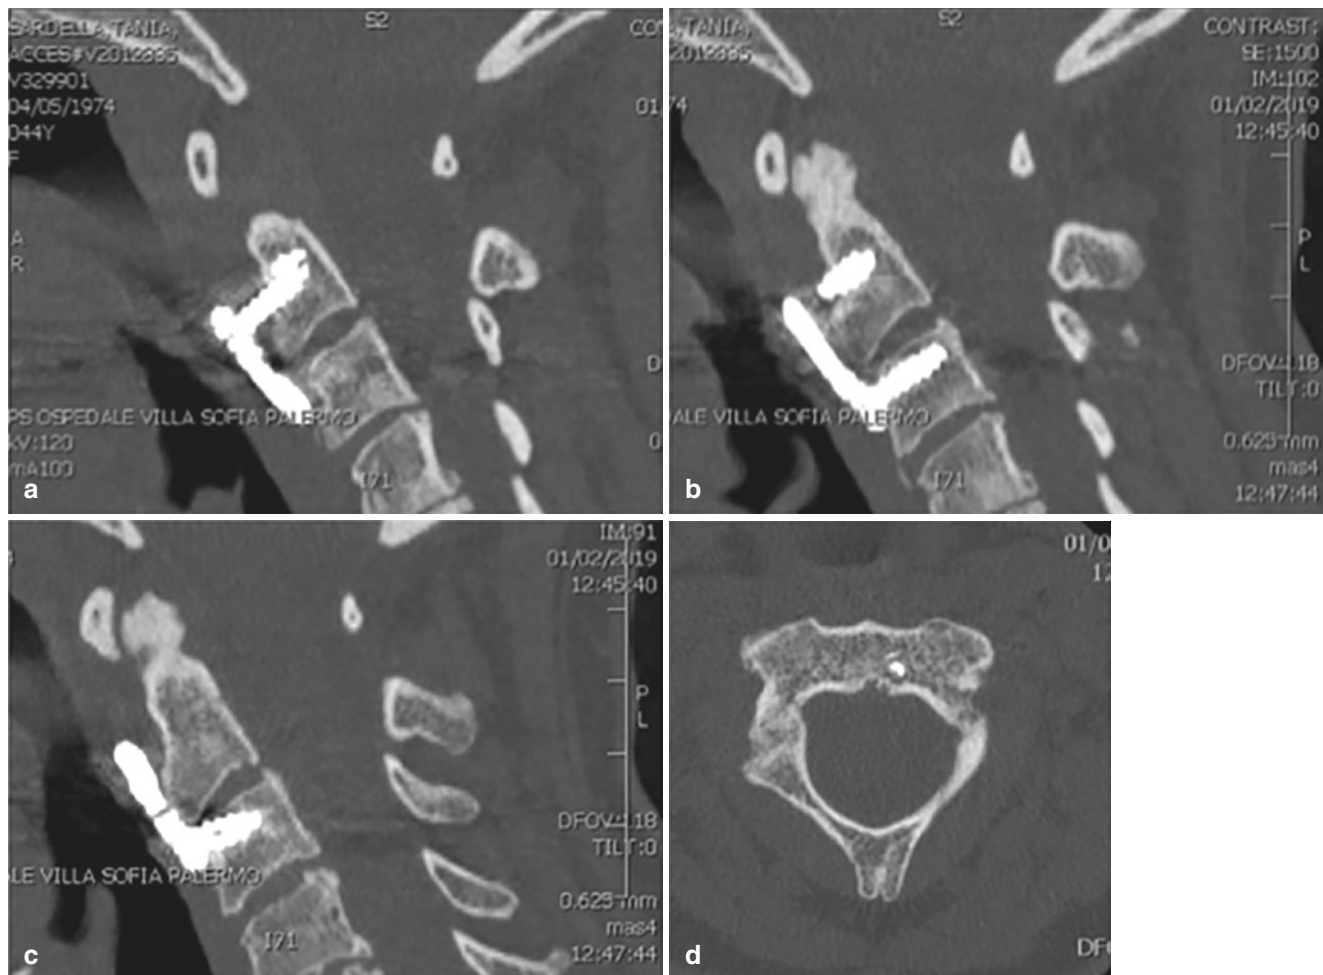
Several 6-month postoperative CT scans: (a–c) sagittal scan document with satisfactory C2–C3 alignment and anterior plate fixation without complications; (d) a postoperative axial scan documenting
